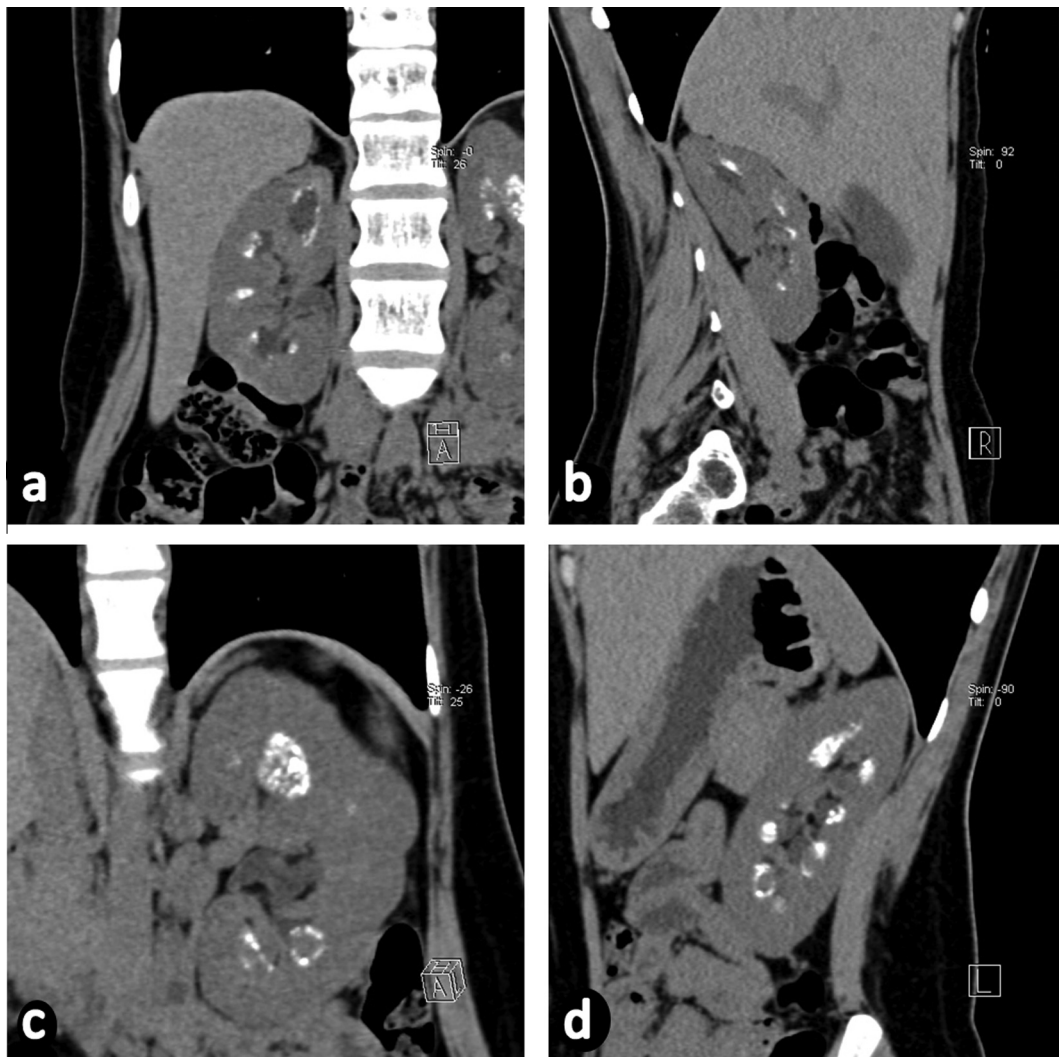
Fifteen year old female patient with bilateral flank pain. CT stone protocol through right kidney in oblique coronal (a) and oblique sagittal (b) and through the left kidney in oblique coronal (c) and oblique sagittal (d) planes, shows bilateral renal medullary calcifications with no stones, diagnosed as medullary cystic kidneys.
